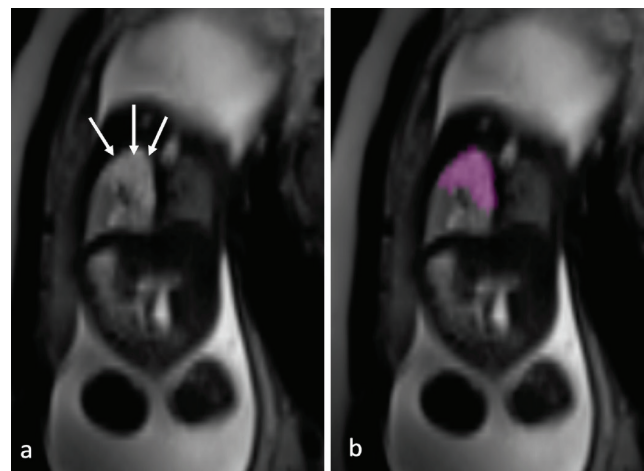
(a) A hyperintense lesion (arrows) is seen in the left lung in coronal T2-weighted fetal MRI. (b) ROI was drawn for the texture analysis
